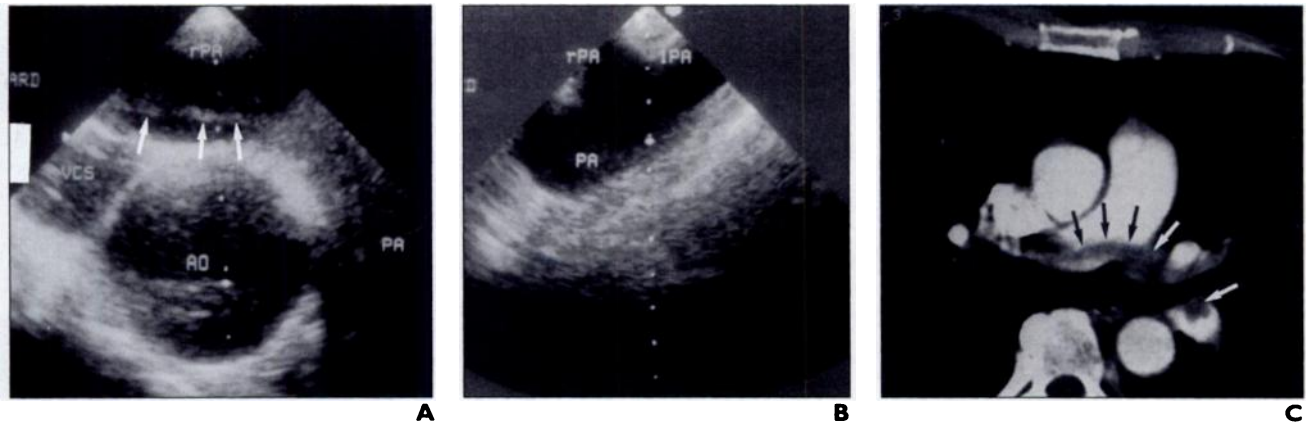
63-year-old man with central left-side pulmonary embolism. Thromboembolic clot was not revealed by transesophageal echocardiography although good visualization of left pulmonary artery was achieved. This patient also had no pathologic indirect parameters.
